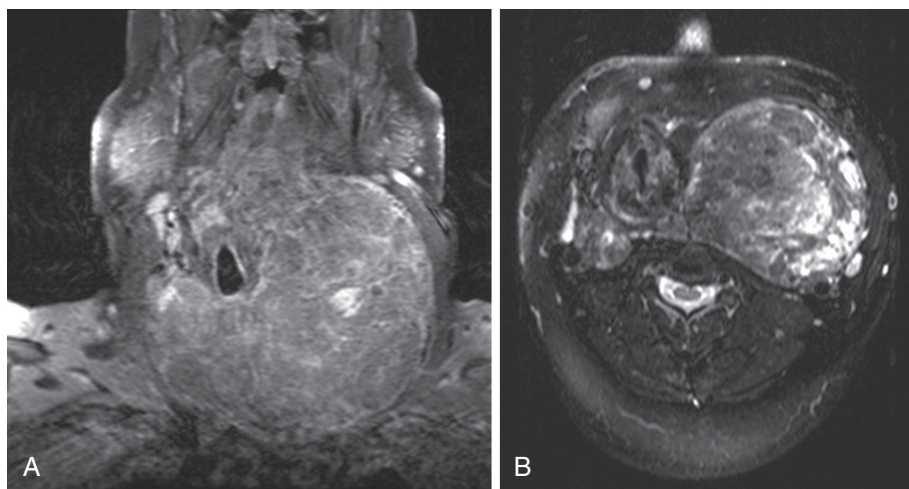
Thyroid goiter. Magnetic resonance images show a massive goiter in a 55-year-old man who presented with a change in his voice and increased shortness of breath. Endotracheal intubation required flexible bronchoscopy, followed by uneventful resection of a 900-g multinodular goiter. Coronal (A) and axial (B) gadolinium-enhanced images of the neck reveal tracheal deviation and compression.
